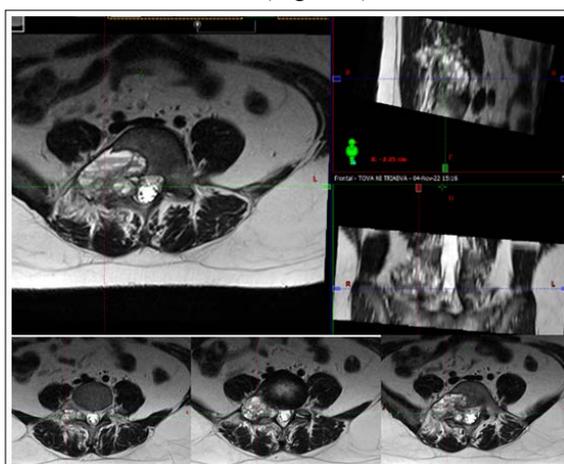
Spine MRI/ November 2022
